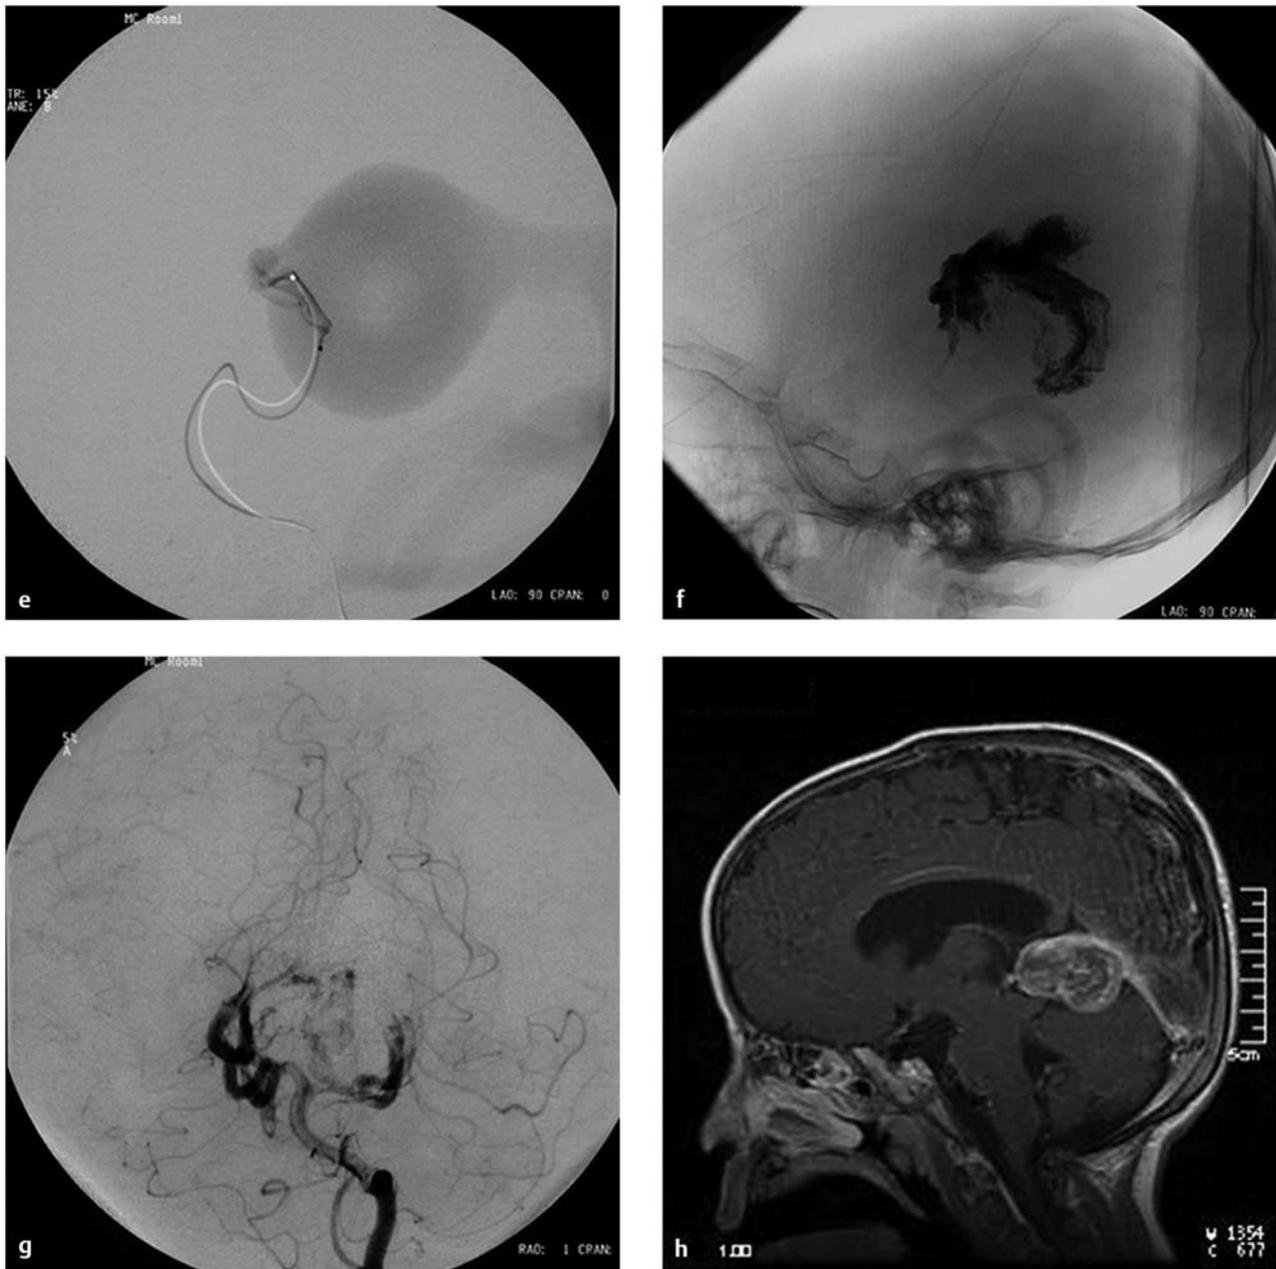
(continued) (e) Superselective angiogram of the left posterior choroidal artery showing a high-flow fistula. This was embolized with *N*-butylcyanoacrylate (NBCA). (f) Lateral skull film showing the NBCA cast penetrating into the venous side. (g) Left vertebral angiogram in the AP view after one NBCA embolization demonstrating almost complete obliteration of the fistulas with minimal residual shunting, showing that this VGAM was a single-hole mural-type fistula. (h) T1-weighted sagittal MR image with contrast 5 months after the embolization demonstrating complete thrombosis and shrinkage of the dilated vein. The ventricular size also decreased without ventriculoperitoneal shunt. The patient remained neurologically normal with normal development.
